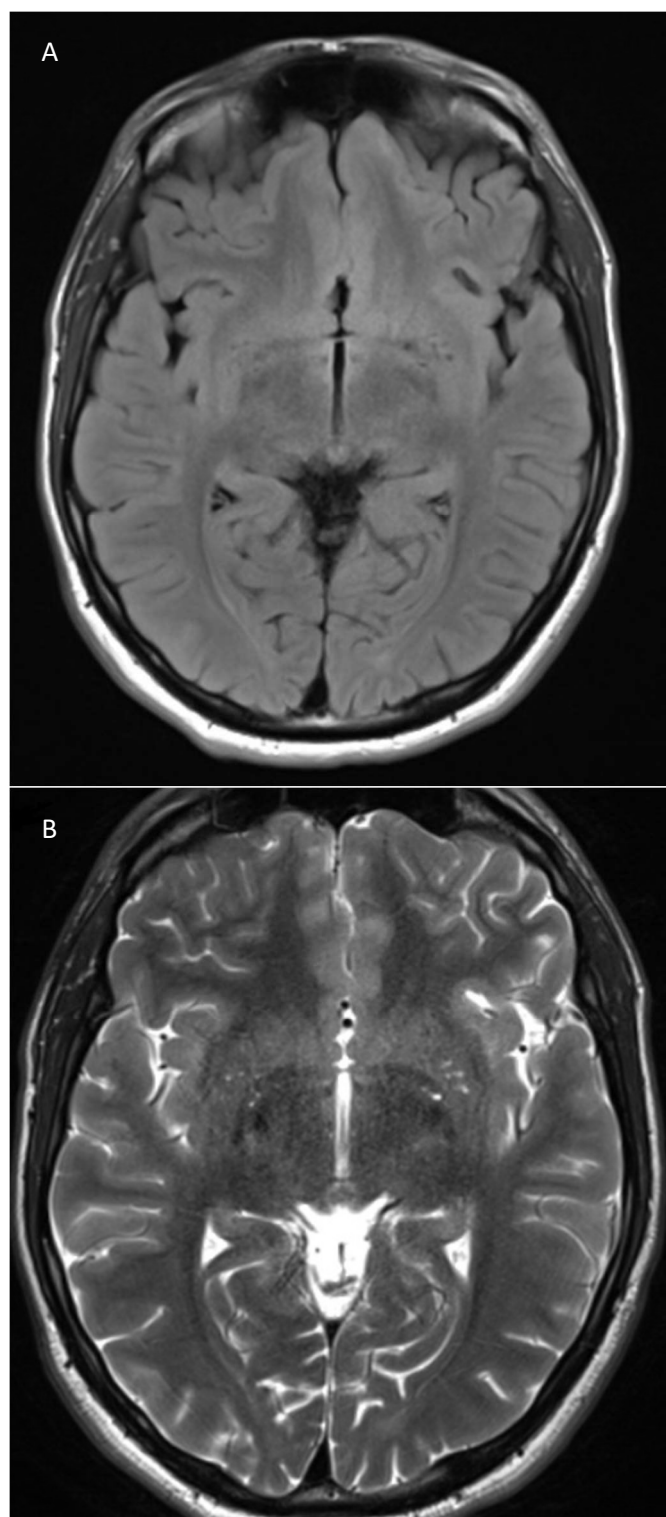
Axial FLAIR (A) and T2-weighted MRI
